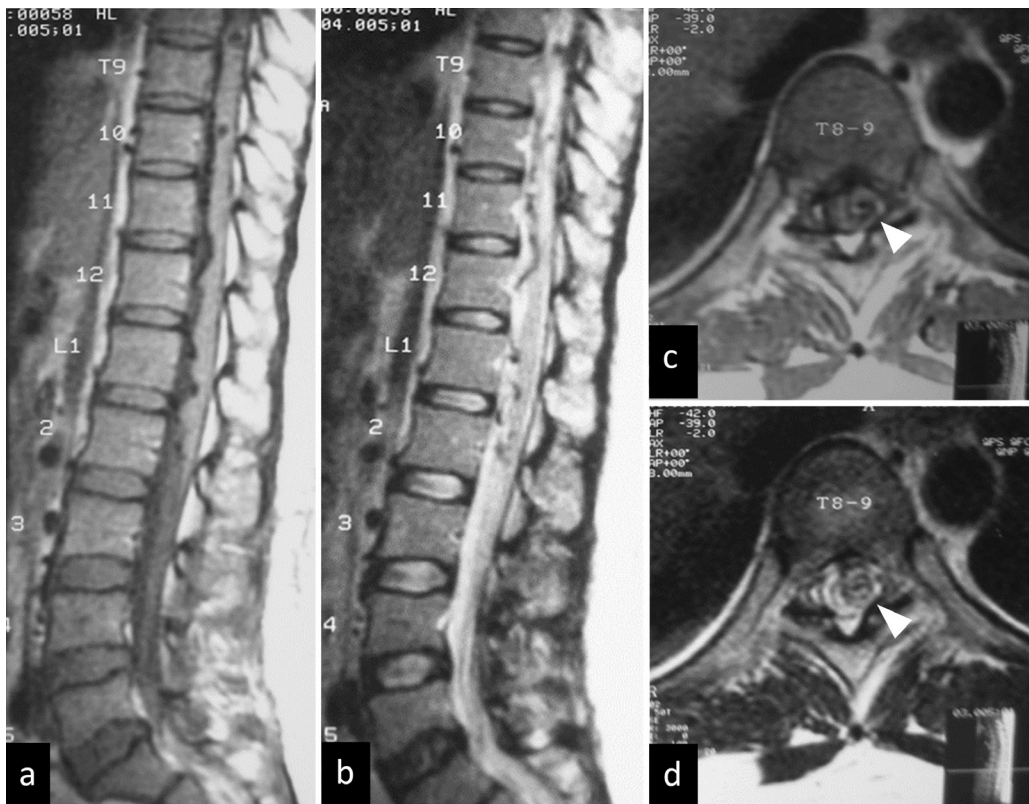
Sagittal (A) T1-weighted and (B) T2-weighted images of the thoracolumbar spine reveal serpiginous intradural flow voids along the anterior surface of the spinal cord extending from the level of L2 to the mid-thoracic. Axial (C) T1-weighted and (D) T2-weighted images at the level of T8–9 demonstrate abnormal heterogeneous signal intensity (*arrowheads*) on the left side of the spinal cord, probably representing intramedullary hemorrhage.
